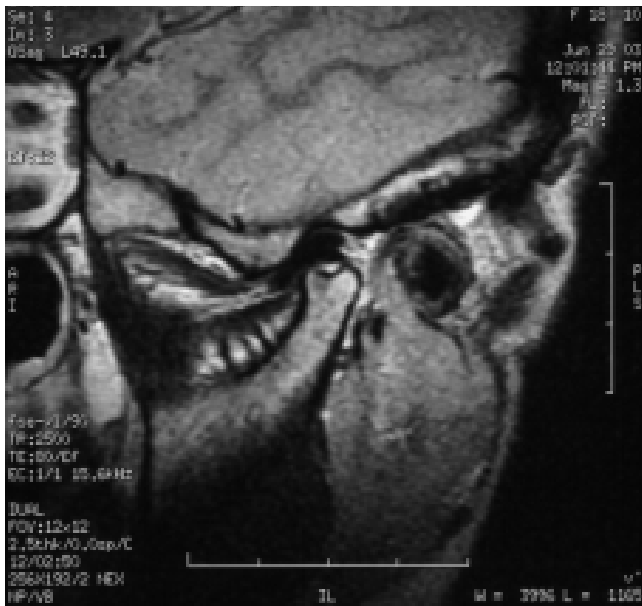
MRI examination in the sagittal (TR-550 and TE-15) plane revealing left bifid condyle heads.
